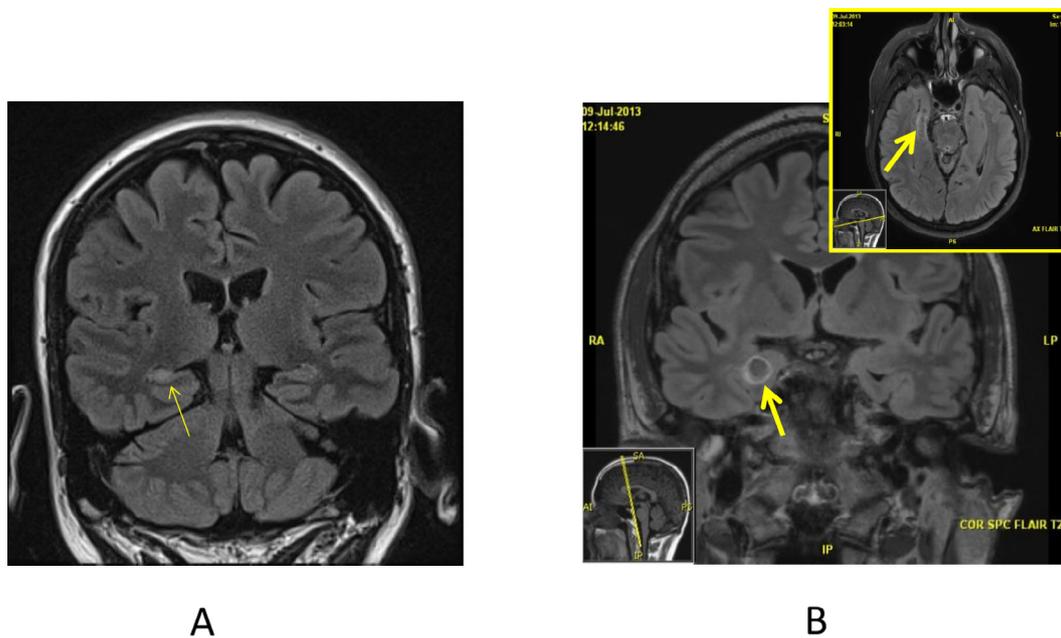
(A) Pre-operative Brain MRI demonstrating right MTS (thin arrow) and (B) post-LITT in the coronal and transverse (insert) plane demonstrating ablated amygdalohippocampal complex (thick arrow). Post-operatively the patient has remained seizure-free.
